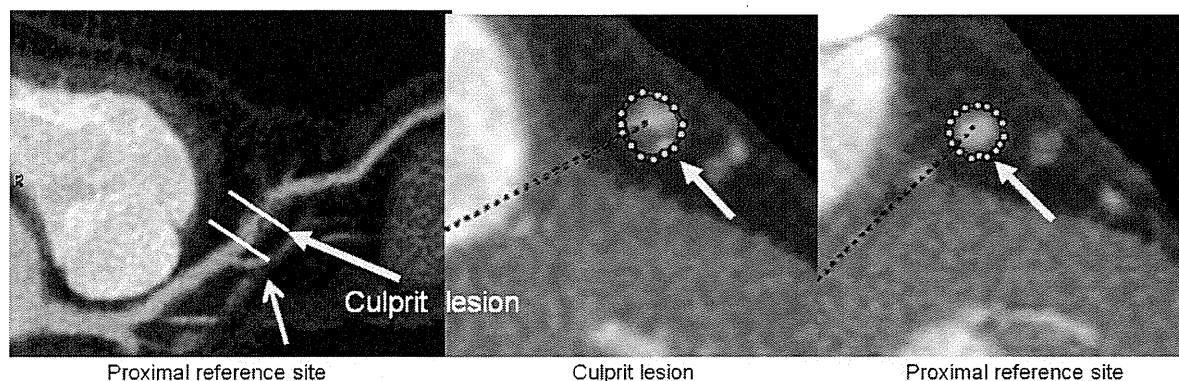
Definition of remodeling index (culprit area/proximal reference area) in multislice computed tomography (CT). Curved planar reformation images of left anterior descending branch (LAD) (left figure) and short axis images perpendicular to long axis of LAD at 1) culprit lesion (middle figure) and 2) proximal reference site (right figure) made from left figure. Vessel size surrounded by green dots was larger in culprit lesion than in proximal reference site, which suggests presence of positive remodeling. Remodeling index (RI) was defined as the ratio of the cross-sectional area (CSA) of the vessel wall at the culprit lesion site to the CSA of the vessel wall at the proximal reference site. Positive remodeling categories were defined as having a remodeling index more than 1.05, which is the same definition used in a study employing IVUS.
